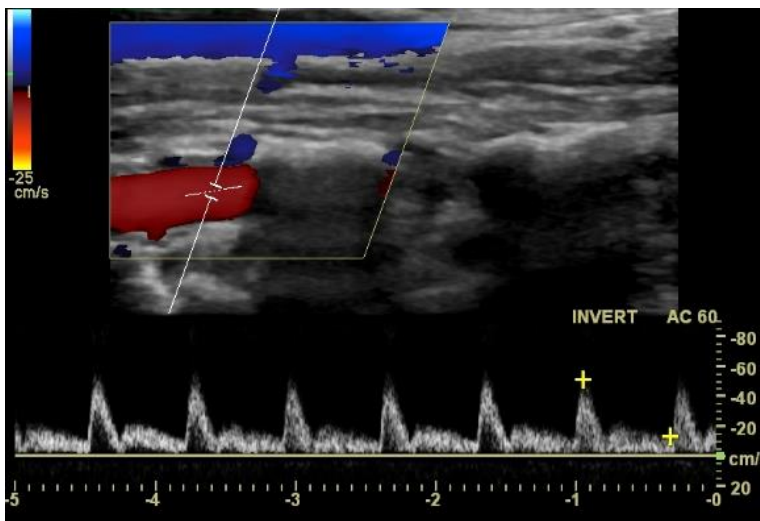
vertebral artery pulse wave Doppler. Note the direction of the flow in relation to the internal jugular vein (Image taken from [180])
